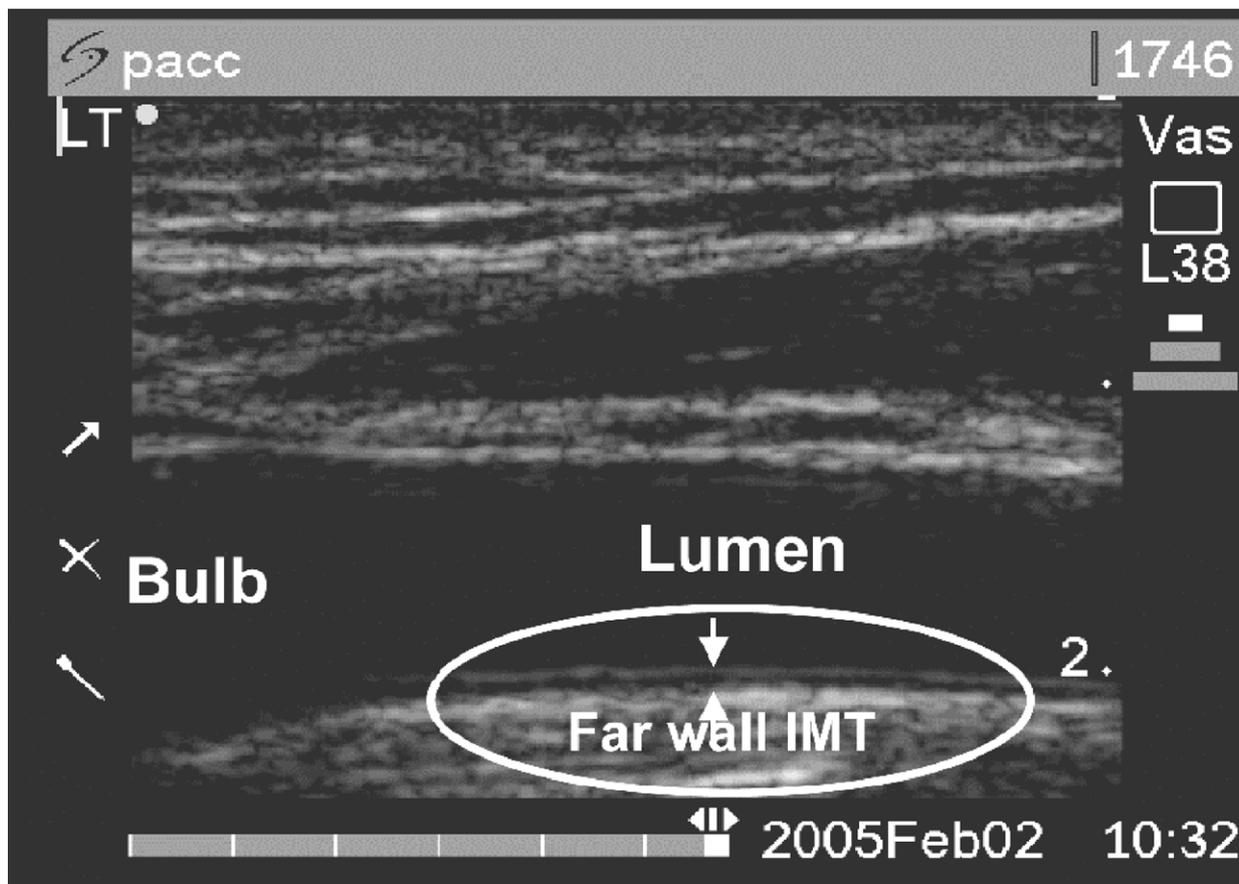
Carotid ultrasound image (10 MHz) of distal common carotid artery. The 2 arrows represent the intimal-luminal and medial-adventitial interfaces, which collectively border the CIMT. In this example, intima-media thickness (IMT) was reported as the mean thickness over the distal 1 cm of the far wall of the common carotid artery.
